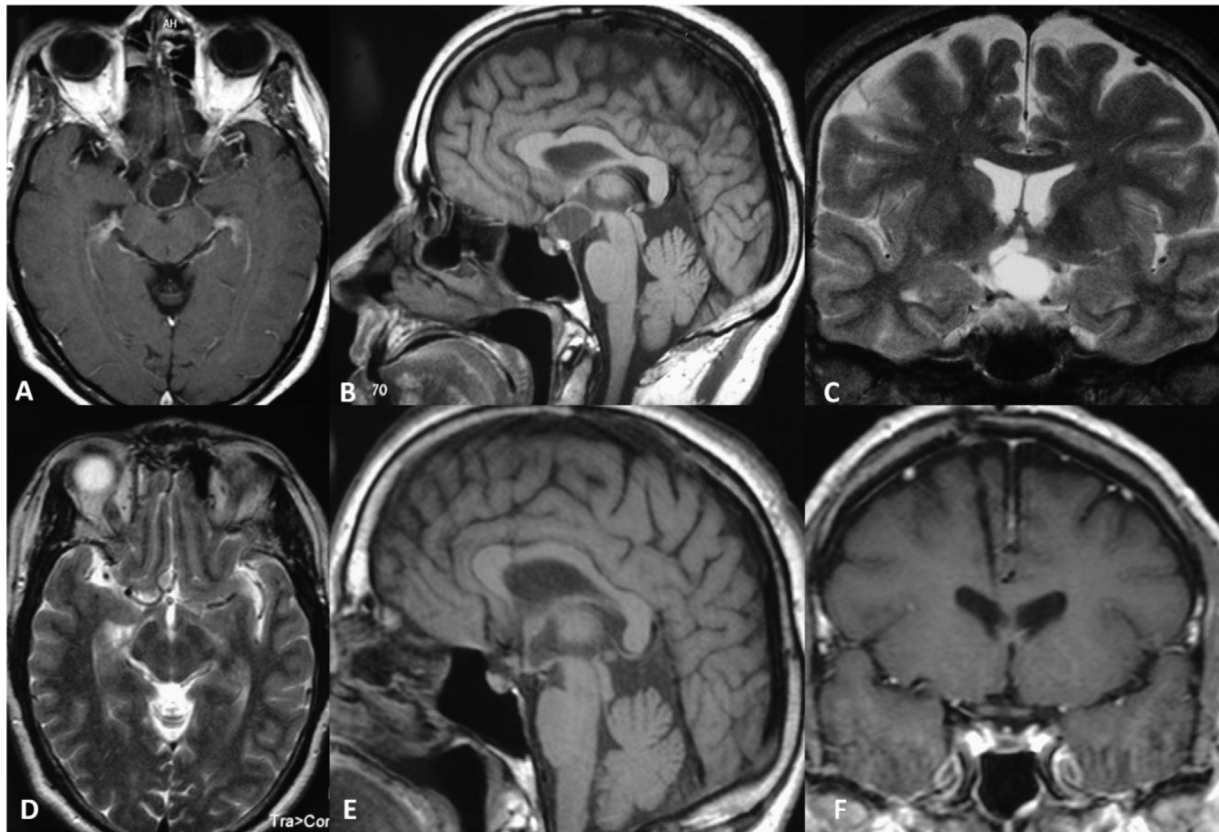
Case 1. An MRI scan showing the cystic craniopharyngioma before treatment: (A) axial T1-weighted image; (B) sagittal T1-weighted image; and (C) coronal T2-weighted image. control MRI 30 months after the treatment: (D) axial T2-weighted image; (E) sagittal T1-weighted image; and (F) coronal T1-weighted image showing complete obliteration of the cyst after stereotactic intracavitary irradiation with colloidal ^{186}Re .
